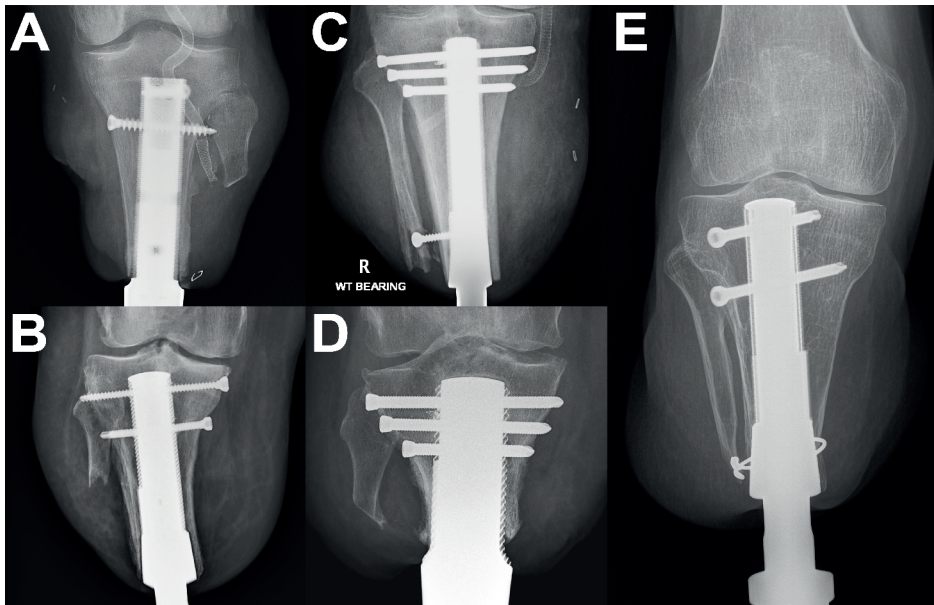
Representative radiographs of the limb containing the osseointegration implant, made at 12 months postoperatively, in Cases 1 (Fig. 3-A), 2 (Fig. 3-B), 3 (Fig. 3-C), 4 (Fig. 3-D), and 5 (Fig. 3-E).
